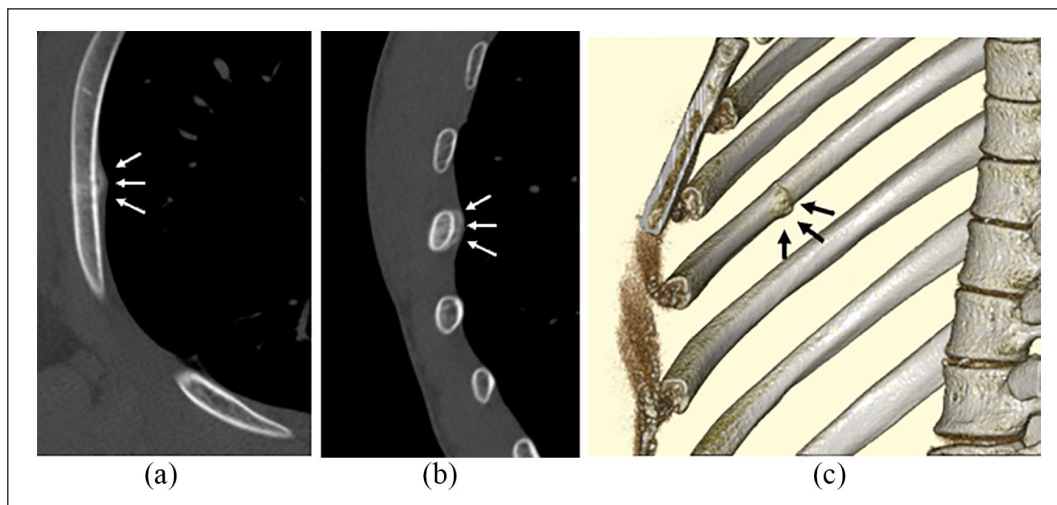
Fracture of the right fifth rib with pleural side predominant callus formation (arrows) on sagittal (a) and axial views (b), and three-dimensional reconstruction (c) on computed tomography.
